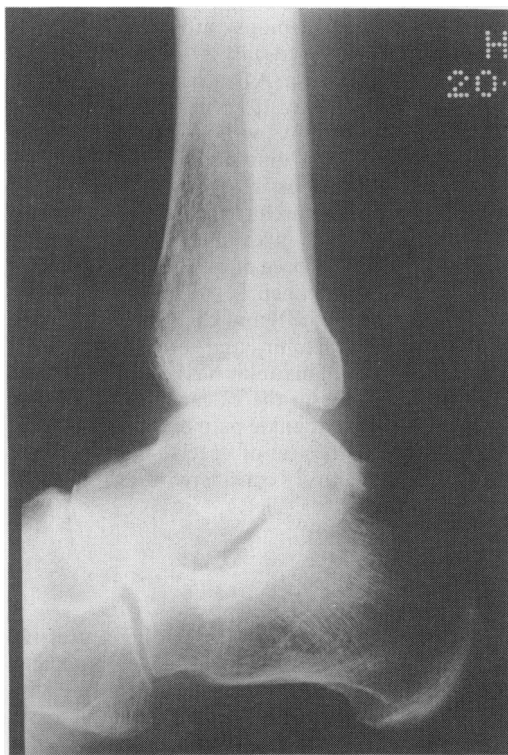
Normal X-ray of ankle at presentation (April 1991).
